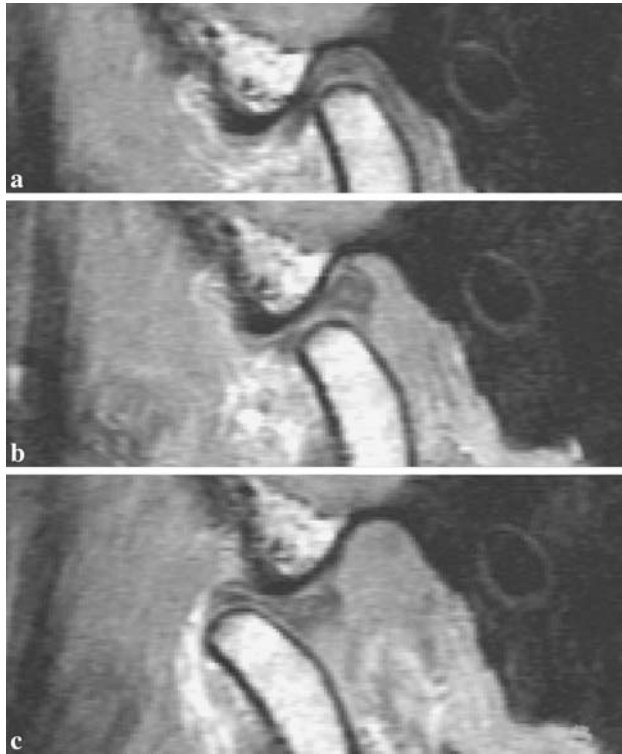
MRI of a normal joint: a closed, b partially open, and c open mouths
